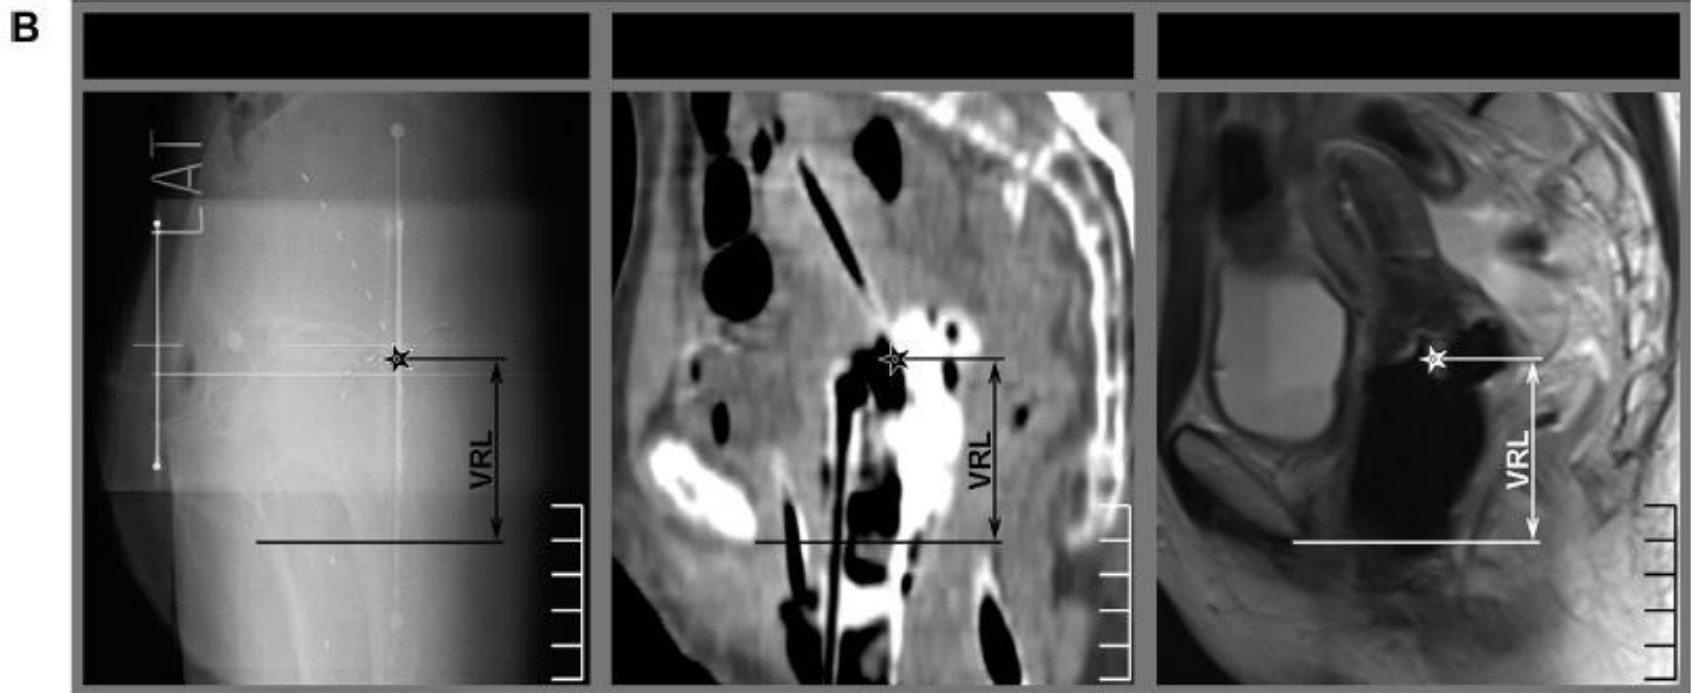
Definition of vaginal dose points and vaginal reference length (VRL). (A) Vaginal dose points are defined in relation to a point at the level of the posterior-inferior border of the symphysis (PIBS) on sagittal (reconstructed) CT or MR images used for EBRT and BT treatment planning. The star at PIBS level represents the vaginal reference point. In the table on the right side mean (SD) and median (min-max) values are given for each level in EBRT and for total dose in EQD2. Additionally, total doses to the top are given for all four clockwise positions at the vaginal surface and 5 mm depth (e.g. median total dose at 3 o'clock is respectively 266 and 115 Gy for surface and 5 mm depth). (B) VRL at time of BT with a ring applicator in situ on a lateral radiograph, sagittal MPR CT image and sagittal MRI view. VRL is measured from centre of the ring (indicated by a star) to the PIBS level, indicated by the solid line orthogonal to the body axis.
